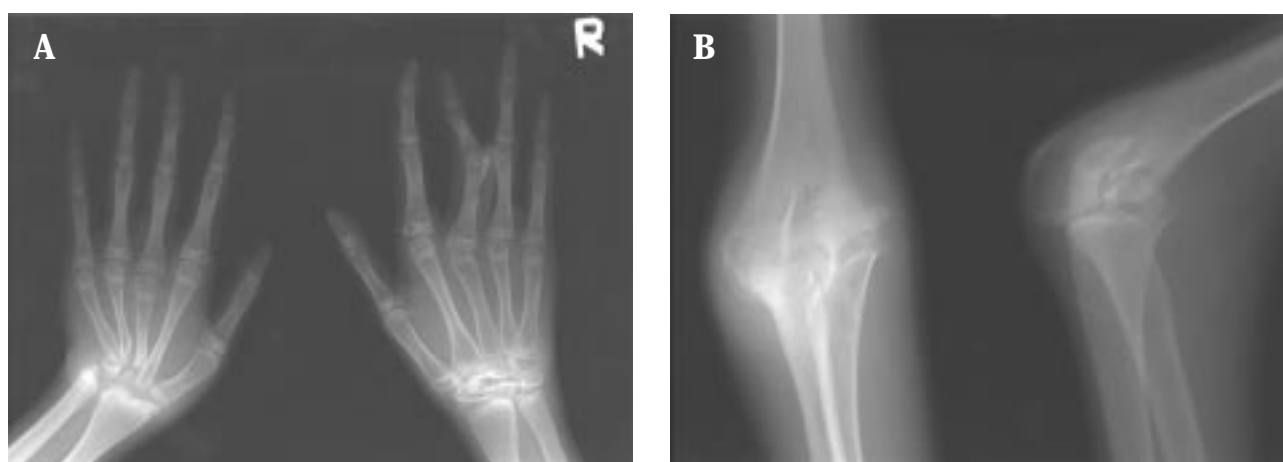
(A) Radiograph of both hands shows vanishing carpal bones and tapering left second to fifth metacarpal bones. (B) Radiograph of the right elbow showing the absence of the medial condyle and relative enlargement of the lateral condyle.
